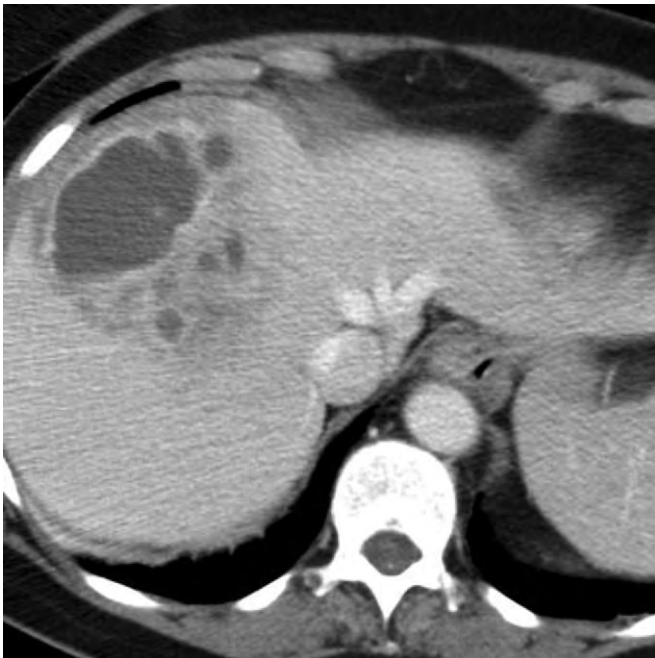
Contrast-enhanced CT through the liver reveals the “cluster” appearance of a pyogenic hepatic abscess with several smaller peripheral abscesses that have coalesced.
